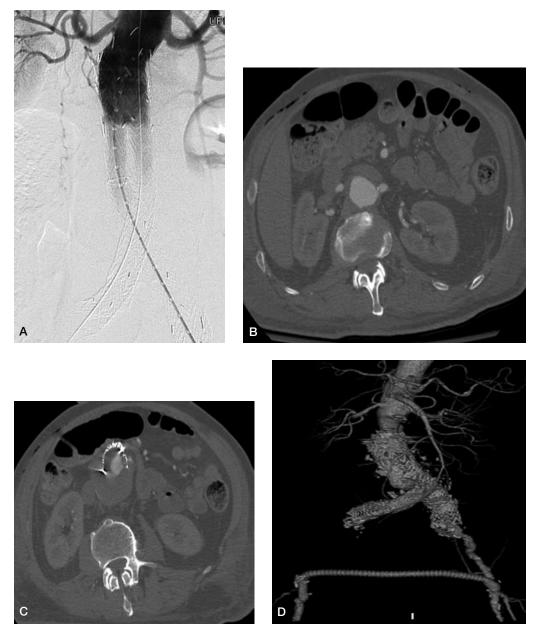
A. Completion aortogram with AAA exclusion following Gore Excluder placement along with aortic cuff extension. B-D. CT angiogram obtained 4 years later in a patient who was lost to follow-up and developed limb occlusion requiring femorol-femoral bypass following an emergent coronary bypass. CT demonstrates distal migration and neck dilation. The patient was treated with conversion using an aortobifemoral bypass following recovery from his coronary bypass.
